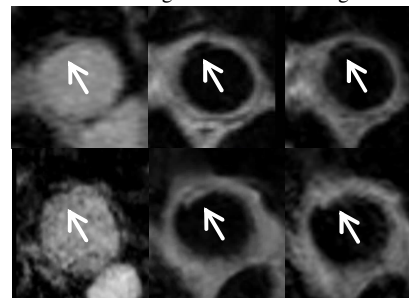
Plaque detection and characterization with multi-contrast MRI: calcified plaque (type VII) represented in the first row and a mobile thrombus (type VI) in second row.
